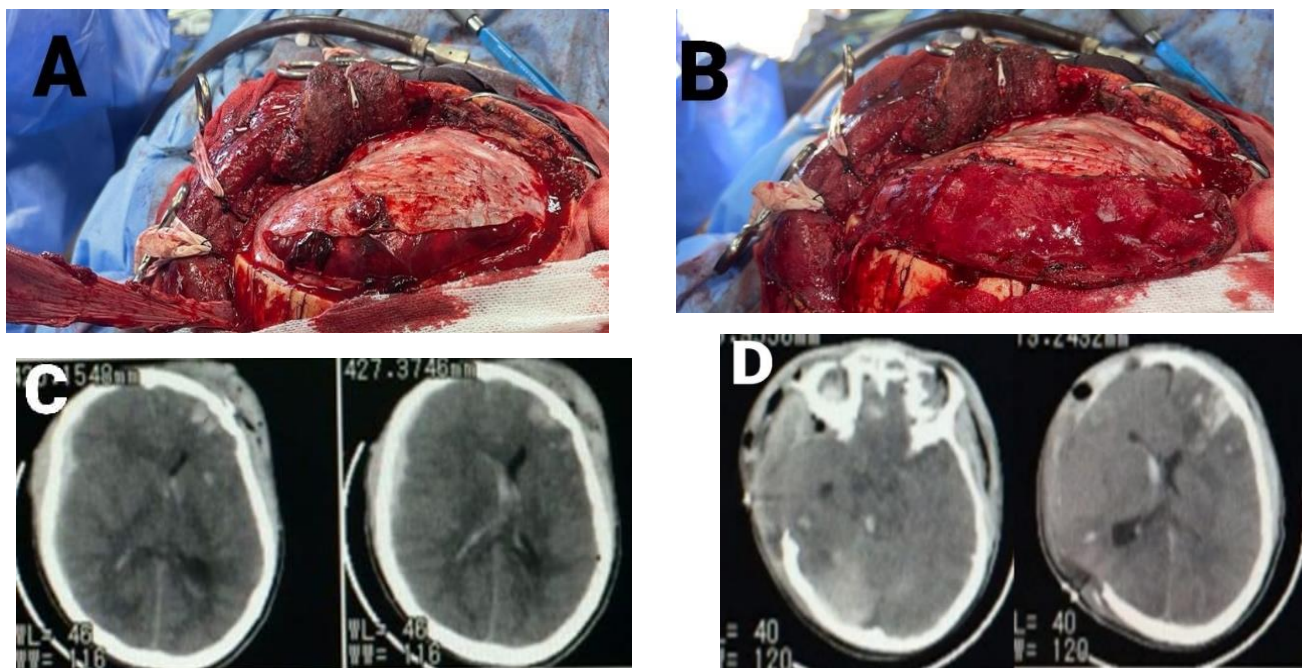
A) and B) Intraoperative photo of right fronto-parietal ASDH with bulging brain after evacuation of the hematoma and DC. Note the pericranium flap was used for augmentative duroplasty. C) preoperative CT scan of the brain, D) postoperative CT scan of the same patient
